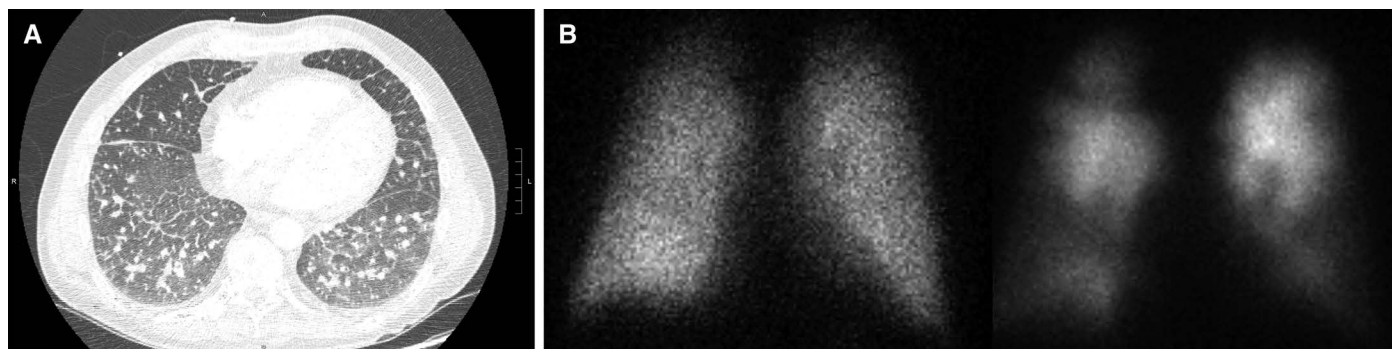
(A) Chest computed tomography with centrilobular ground glass nodules and interlobular septal thickening. (B) Ventilation (left)–perfusion (right) scan with multiple large bilateral mismatched defects.
